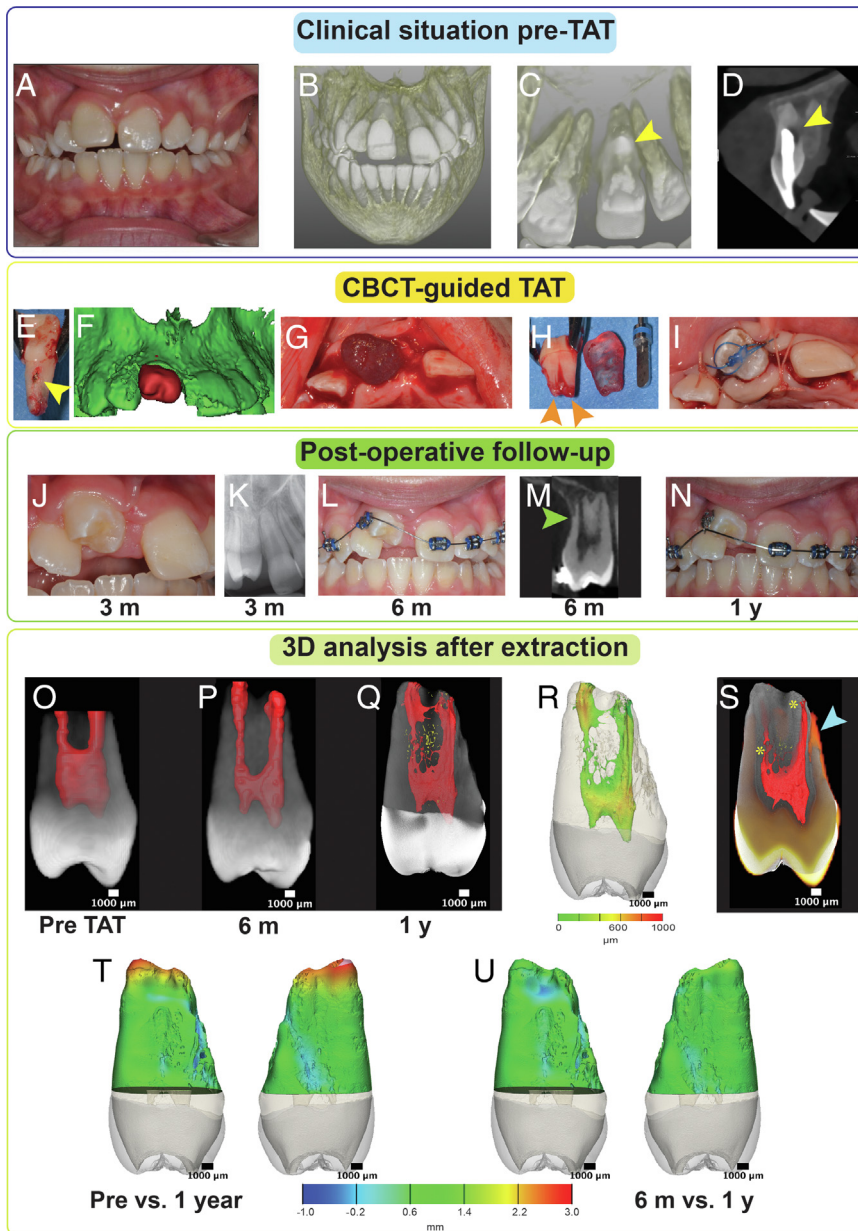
Case 1 (TAT), (A, B) clinical and radiological presentation of ankylotic tooth #8, (C, D) root resorption at the palatal surface (yellow arrowheads), (E) confirmation of the resorption lesion after extraction, (F–I) the surgical process of CBCT-guided TAT, (H) intact apical papilla at TAT (orange arrowheads), (J–N) clinical and radiological follow-up till 1-year post-TAT, (M) detection of ankylosis and replacement resorption at 6 months post-TAT, (O–Q) 3D reconstruction of the transplanted tooth from CBCT scans pre-TAT (O), at 6 months post-TAT (P), and from the nano-CT scan at 1-year post-TAT (Q). (R) color coded map for the root canal system thickness (mean = 269.4 μm \pm 381.7), (S) superimposition of the pre-TAT image (in orange color) on the nano-CT image 1-year post-TAT (in grey values) showing the extent of root resorption (blue arrowhead) and highlighting the newly formed dentin post-TAT (yellow asterisks), (T) surface distance map for root tissue change post-TAT, the root surface resorption extended to -853.5 μm , while the hard tissue gain extended to 3238.6 μm (mean = 333.5 μm) at 1 year post-TAT, (U) between 6 months and 1 year post-TAT, the root surface resorption extended to -1289.1 μm , while the hard tissue gain extended to 1276.1 μm (mean = -26.4 μm). CT, Computed tomography; TAT, Tooth autotransplantation.
